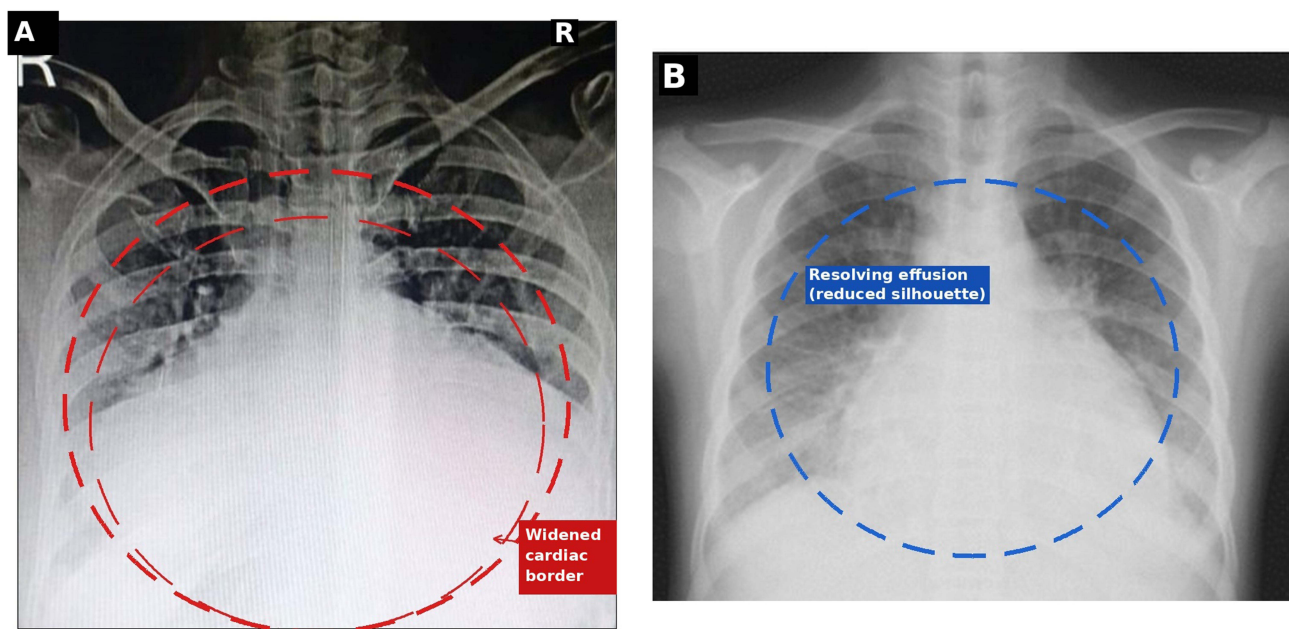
Serial chest radiographs demonstrating resolution of pericardial effusion. (A) Initial chest radiograph (posteroanterior view) showing a markedly widened cardiac silhouette with a cardiothoracic ratio greater than 0.55, consistent with a massive pericardial effusion. R = right side of patient. (B) Follow-up chest radiograph demonstrating significant reduction in the cardiac silhouette, indicating near-complete resolution of the pericardial effusion following treatment.
